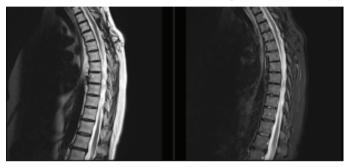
Follow-up T1 and T2- weighted MRI images of first case MRI: Magnetic resonance imaging
